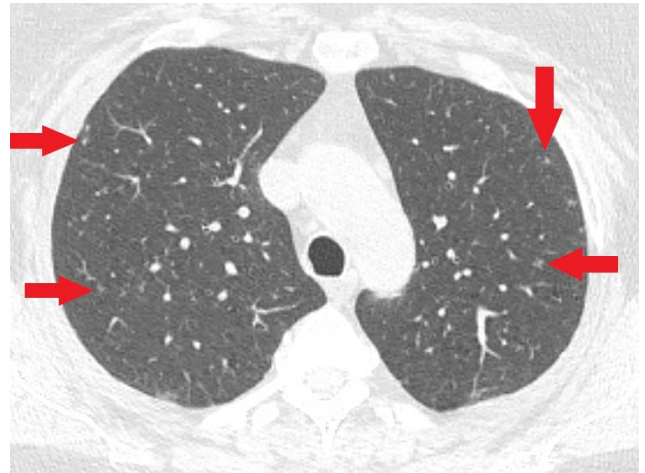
Non-contrast CT chest showing small bilateral upper lobe nodules (red arrows).
